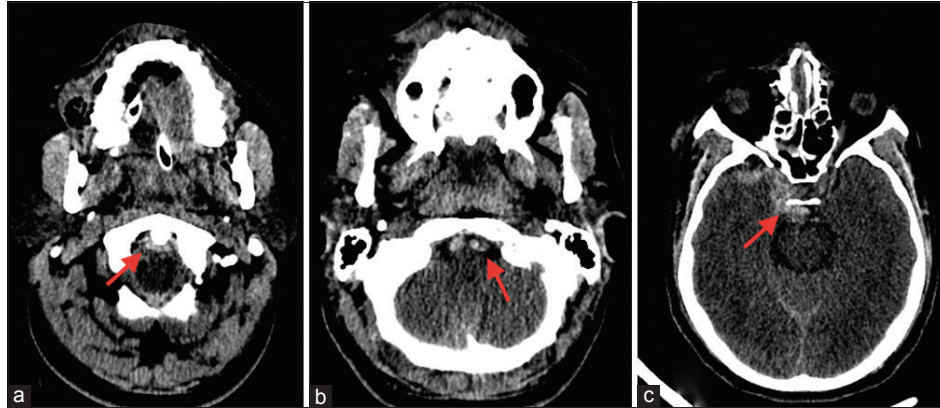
Axial computed tomography scan with subdural hematoma (red arrows). (a) Odontoid level, (b) bulbar level, (c) mesencephalic level.
